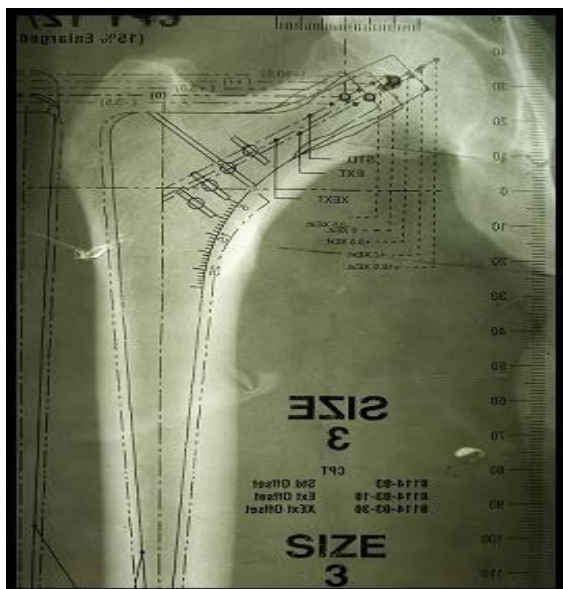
Templating for cemented femoral component on anteroposterior radiograph.
